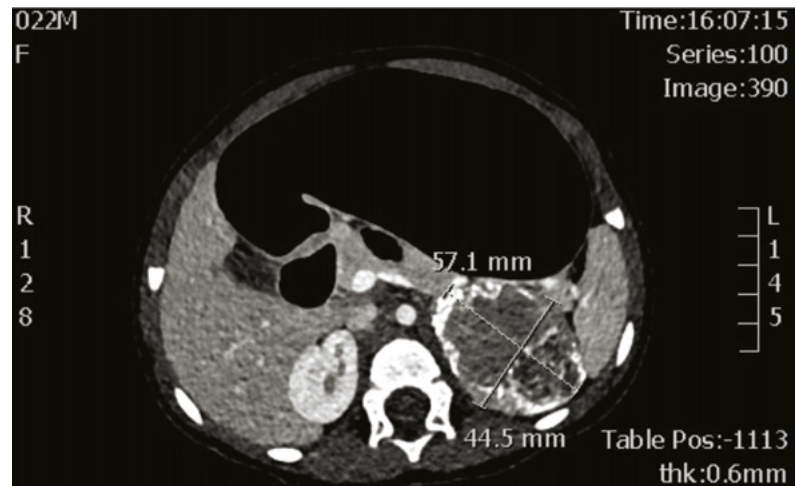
Computed tomography showing a well-defined left-sided lesion with soft tissue and calcific densities.
